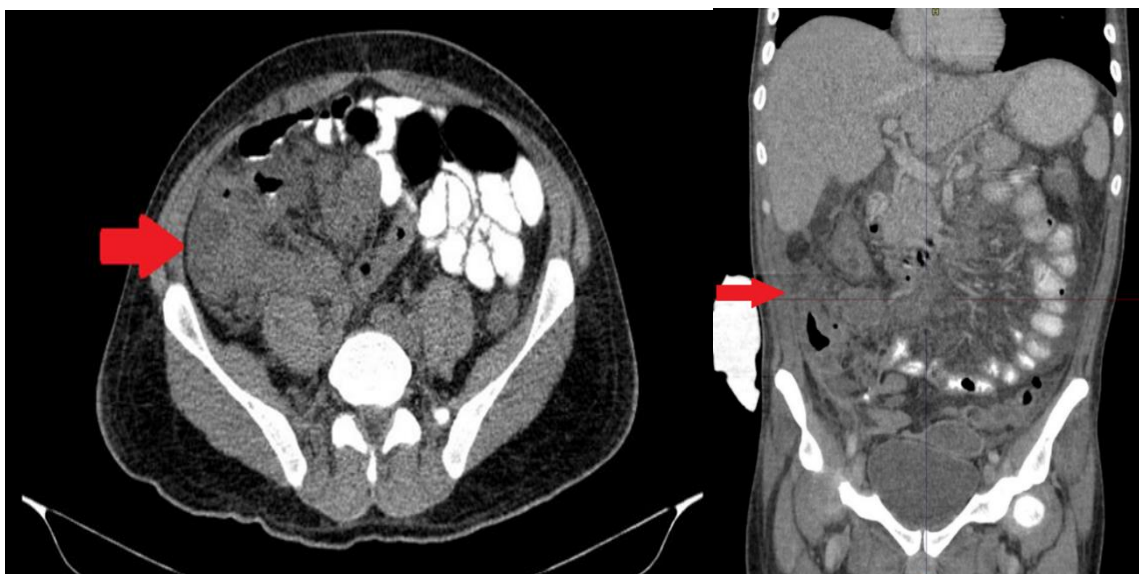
CT scan showing mass in the retroperitoneal epi and mesogastrium region with a 4.5 cm heterogeneous solid-liquid mass.
